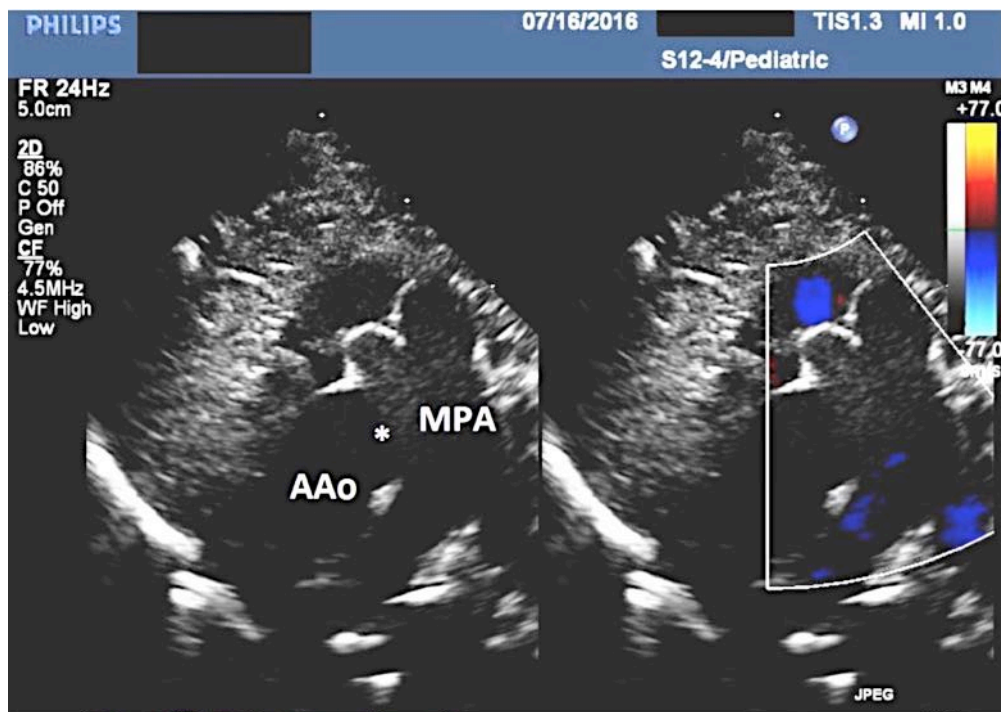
Echocardiogram image of the Aortopulmonary Window. AAo = ascending aorta; MPA = main pulmonary artery; * = Aortopulmonary Window.
